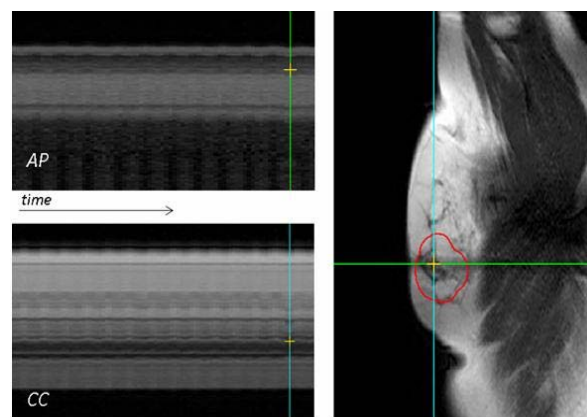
Time-stacks (left) of two perpendicular lines through the yellow indicator in the corresponding sagittal plane (right), acquired with an interval of 0.6 s during 2 min, and an in-plane resolution of 1 mm on preoperative cine-MRI. The time-stacks show intra-fraction motion of a breast tumor in the anterior-posterior (AP, top) and caudal-cranial directions (CC, bottom) of one patient. The CTV delineation is depicted in red.
